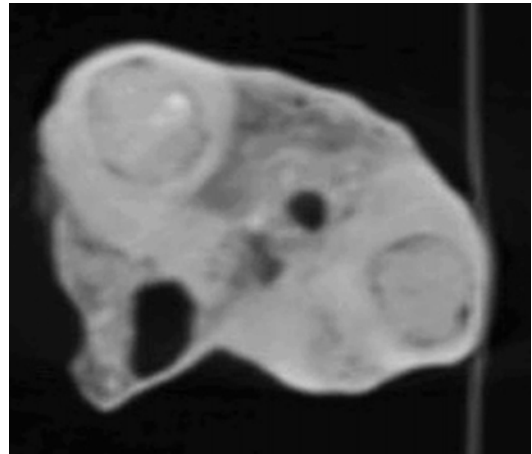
CT scan axial plane multiplanar reconstruction shows the distance between fracture stumps and their lack of contact. However, the bone callus envelops both stumps into calcified repairing tissue
